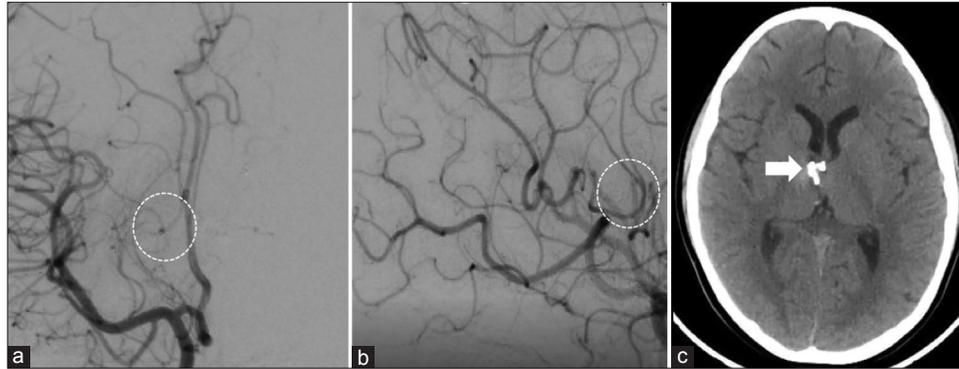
Six-month angiographic follow-up. (a) Right internal carotid artery (ICA) in frontal view demonstrates the absence of the arteriovenous malformations nidus (dotted circle). (b) Right ICA in lateral view shows a complete obliteration of the nidus (dotted circle). (c) Non-enhanced brain computed tomography shows the embolization material in the anteromedial part of the right thalamus (arrow).
